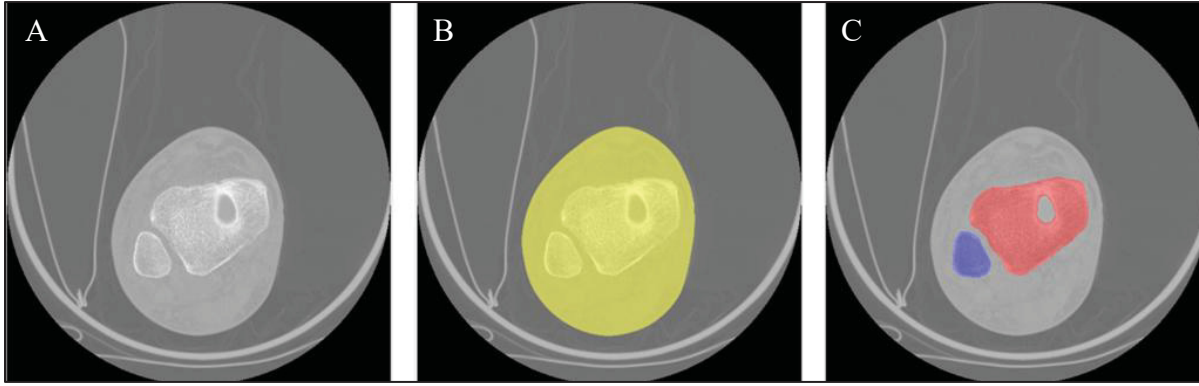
A sample of CT scan slice (A), the segmentation of the foot (B) and segmentation of Tibia and Fibula bones in red and blue respectively (C)
